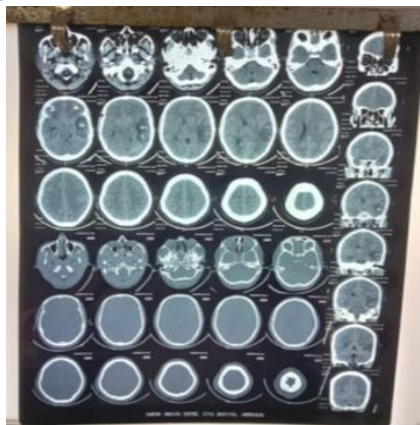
Pre operative CT scan showing left temporo parietal contusion
